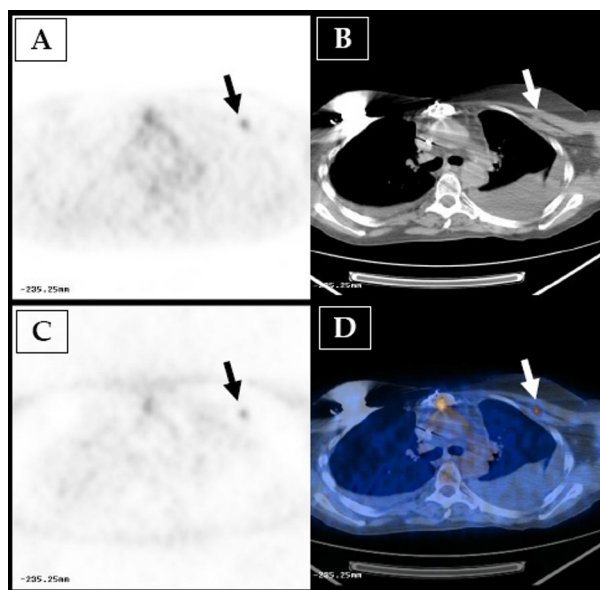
Axial 18F-FDG PET/CT scans showing an intensely hypermetabolic focus (arrows, SUVmax of 3.8) in the left pectoral muscle, corresponding to a nodal metastasis: A, uncorrected PET image; B, CT image; C, corrected PET image; and D, fused PET/CT image.
